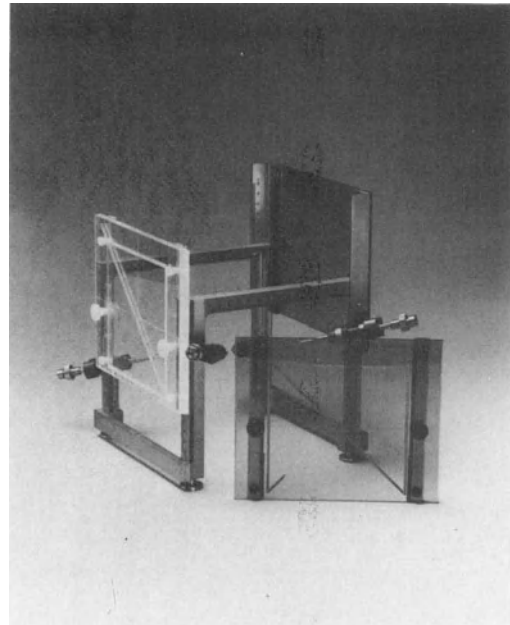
The three different coordinate indicator plates for radiography, CT and MRI.
